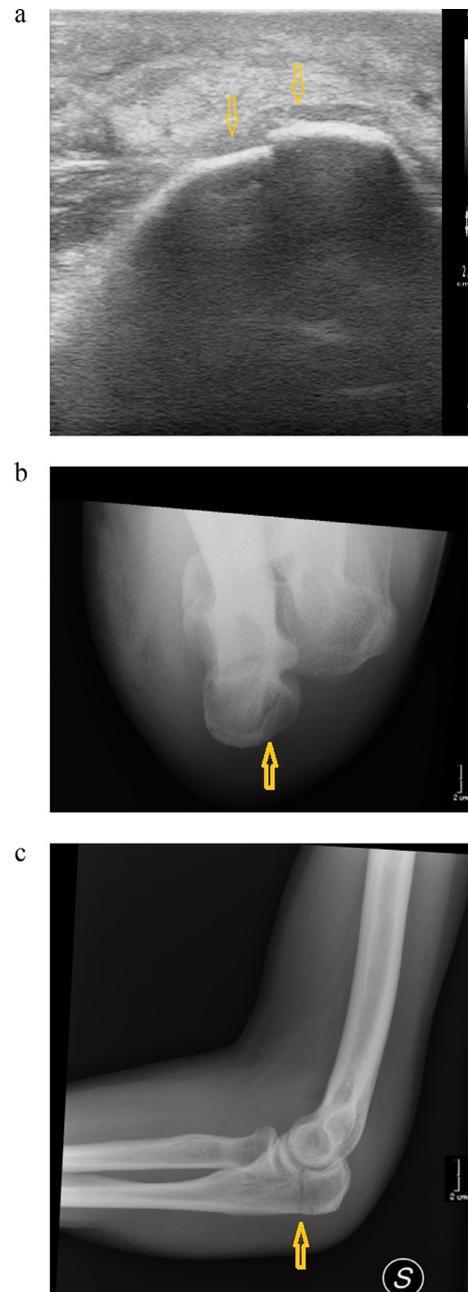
(a) Ultrasound image (transverse axis) of olecranon fracture. The *yellow arrow* points to the discontinuity of the cortical bone, expression of fracture. (b) X-Ray image (transverse axis) of olecranon fracture. The *yellow arrow* points to the fracture line. (c) X-Ray image (longitudinal axis) of olecranon fracture. The *yellow arrow* points to the fracture line.
